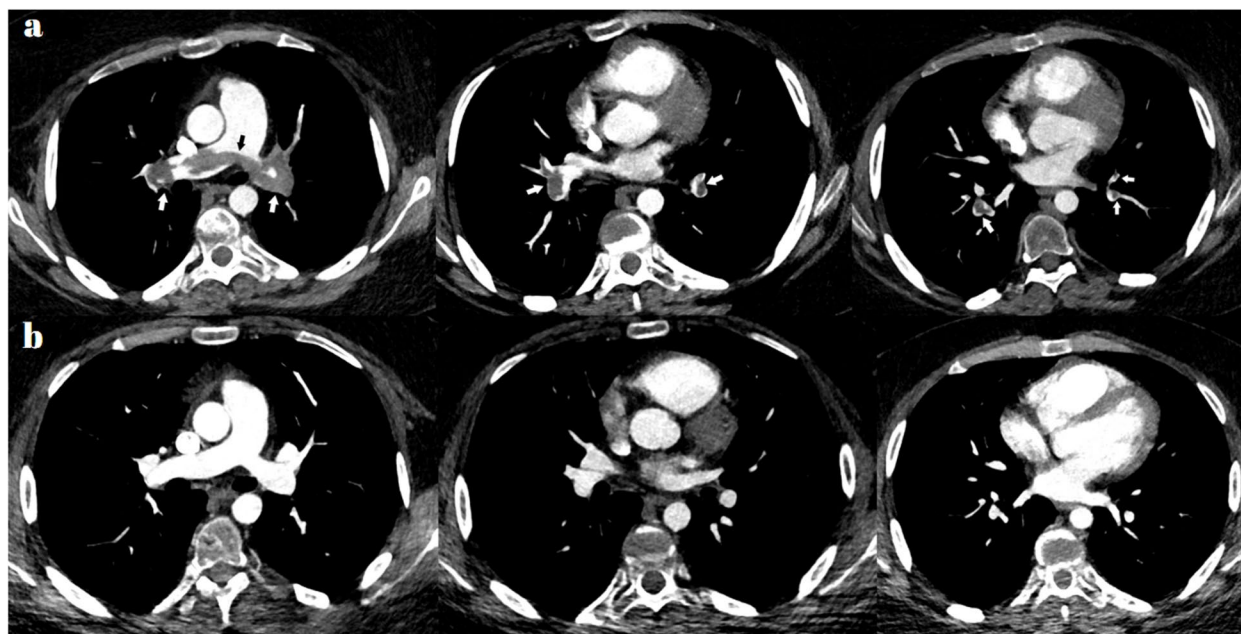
a On pulmonary CT angiography, filling defects (white arrows) extending from the pulmonary trunk to the proximal parts of both pulmonary arteries in a saddle shape (black arrow) and continuing to the segmentary and subsegmentary branches (white arrows) at lower levels. b In follow-up CT examination, it is noteworthy that the thrombus and filling defects in the pulmonary artery and its branches have disappeared
